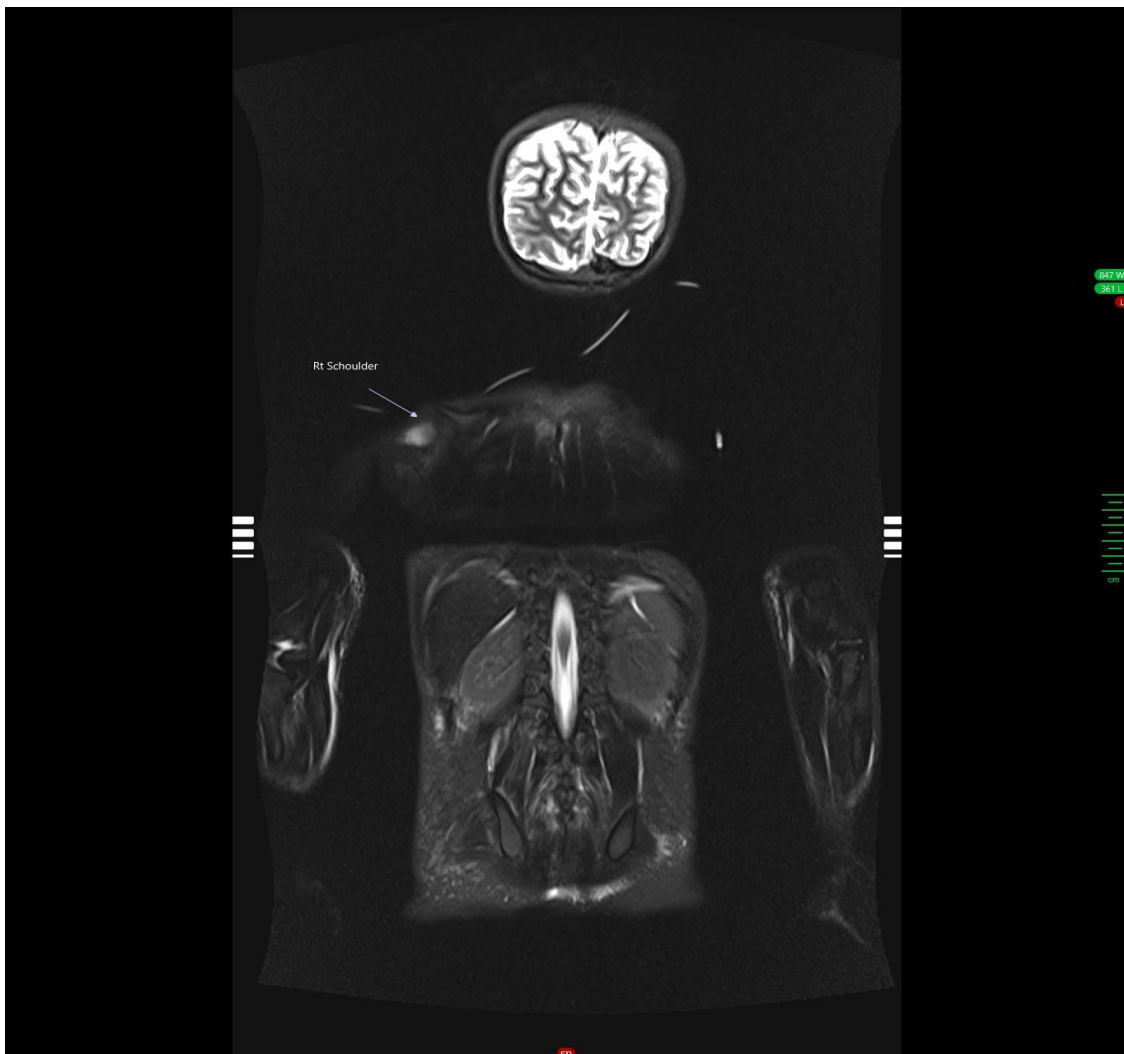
MRI finding: Right shoulder increased muscular signal intensity indicating myositis
